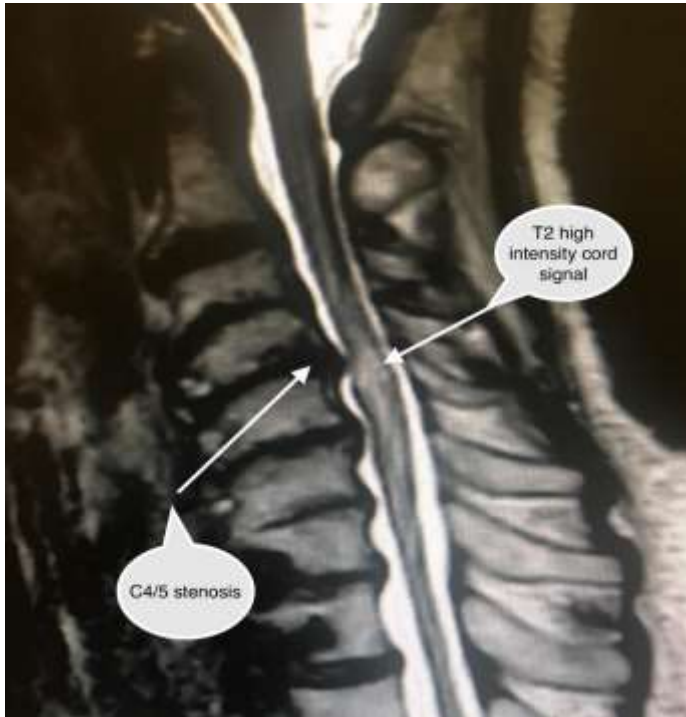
sagittal T2 MRI scan of the cervical spine showing that the most significant compression is at C4/5; this is associated with cord changes in the form of high T2 signal.
